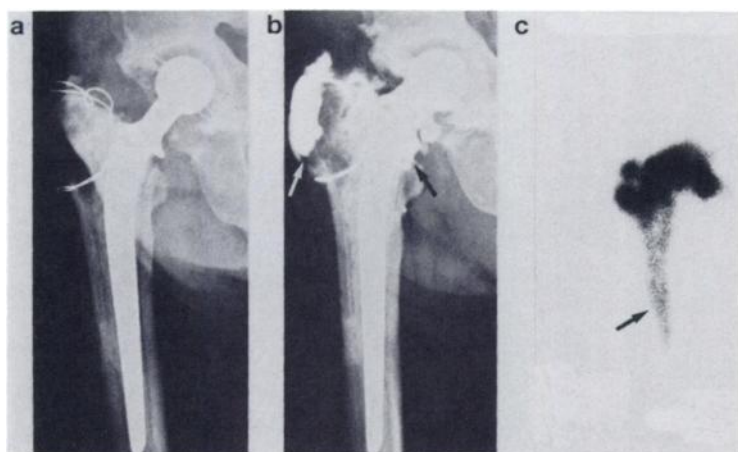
Negative XA and Positive RA. (a) Plain film. (b) XA shows contrast collecting in pocket over greater trochanter (white arrow) and around femoral neck (black arrow). (c) RA: arrow shows activity completely around femoral prosthesis, consistent with loosening.
